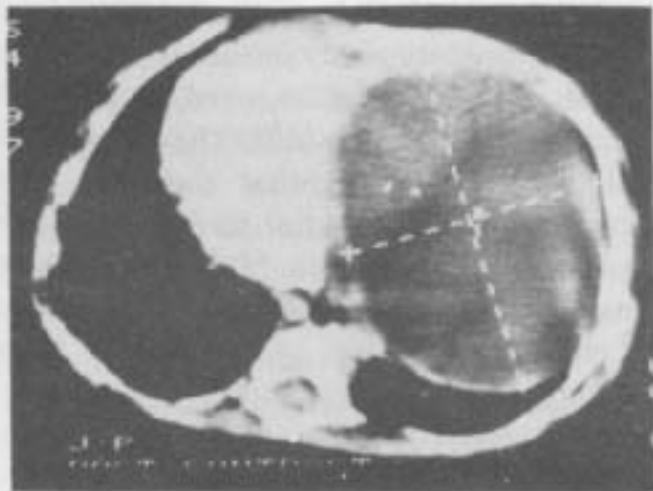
CT scan chest showing cystic mass in left anterior hemithorax.
